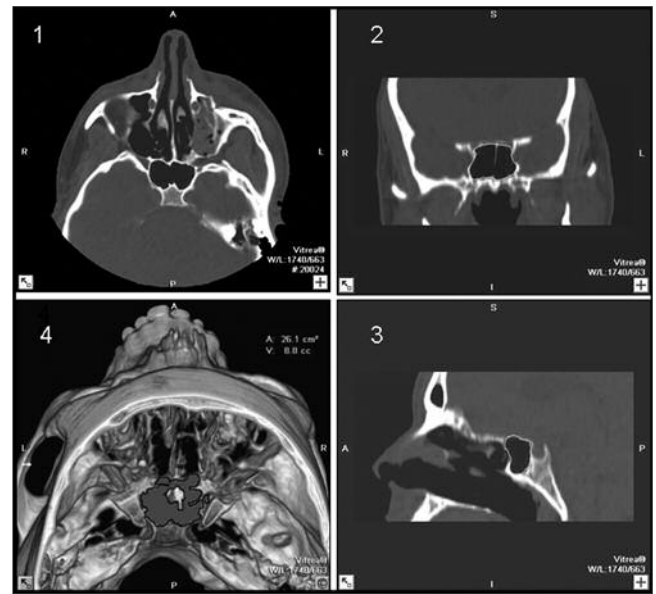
(1) axial view, (2) coronal view, (3) sagittal view, demonstrating the sphenoid sinus limits, (4) 3D-CT image demonstrating volume and area
